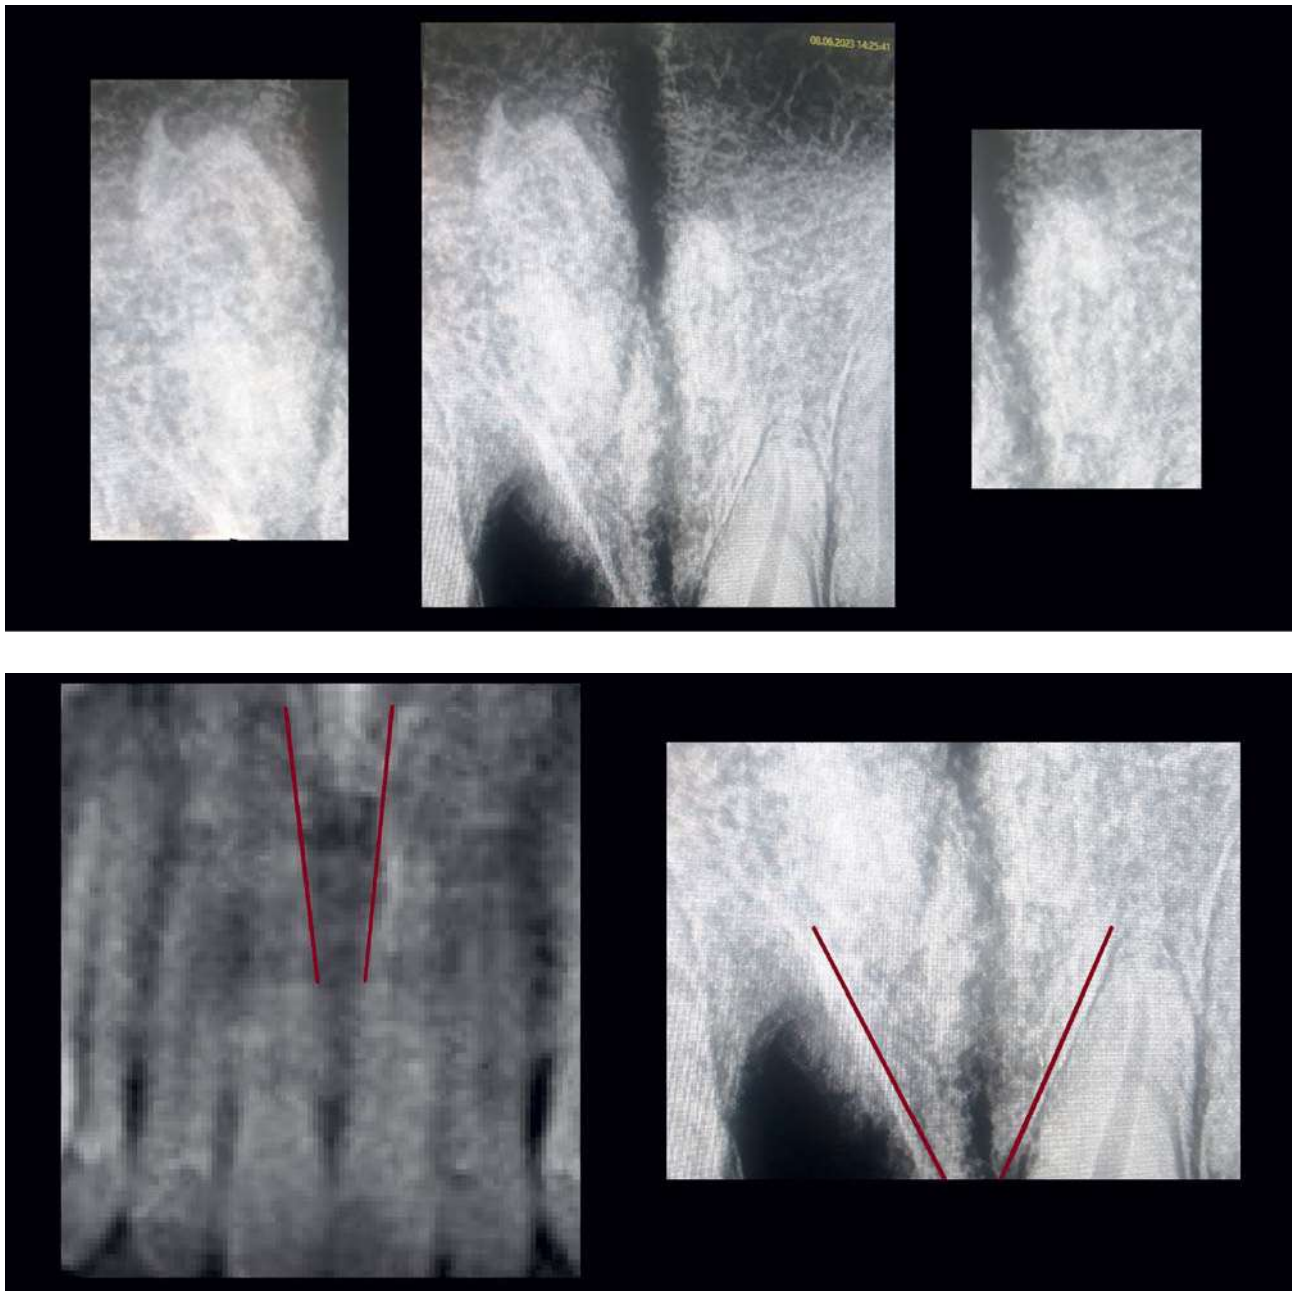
Radiographic investigations, lateral displacements of the alveolar (tooth) socket of the medial incisors are observed, normal alveolar (tooth) socket of the medial incisors.
